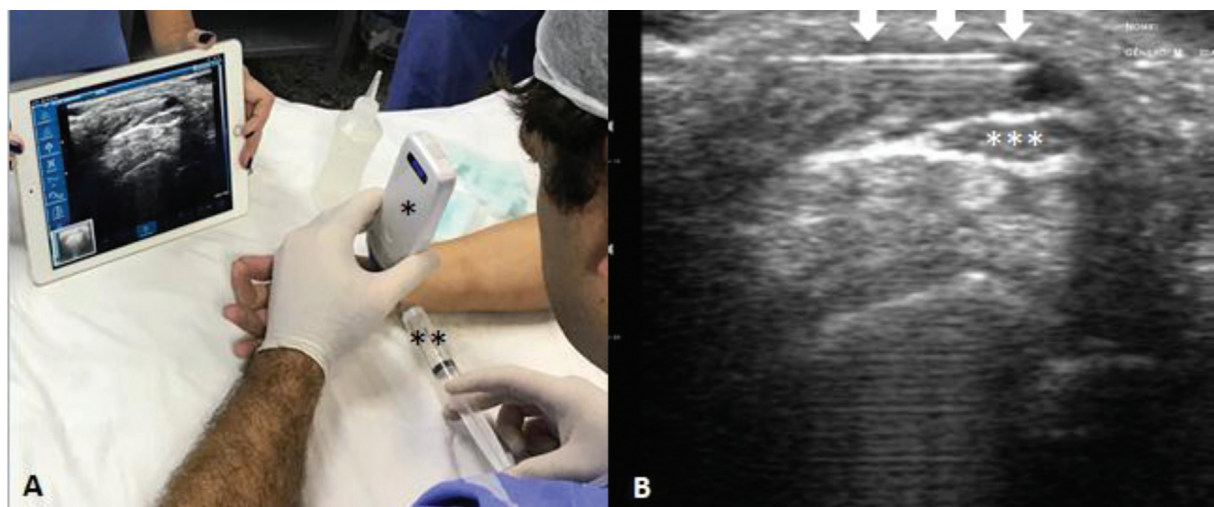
(A) Right upper limb of the patient in supine on the hand table. A portable ultrasound with a linear probe* (Mobissom) is positioned across the wrist, with real-time identification of the median nerve* in the image transmitted to an iPad (Apple). A gray disposable hypodermic needle, measuring 25 mm x 0.70 mm and attached to a 20-ml syringe containing xylocaine solution at 1% with vasoconstrictor is introduced in the ulnar radial direction to the perineurium of the median nerve, according to white arrows (B). Circumferentially, ~ 6 ml to 10 ml are infused around the median nerve.
